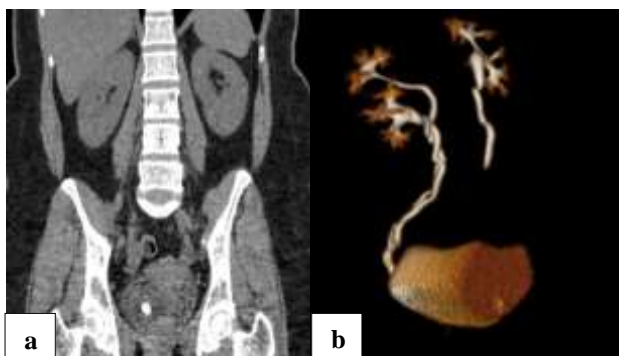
CT-KUB showed the following (a) stone in right lower ureteric orifice, and (b) 3D reconstruction showing complete duplication.
